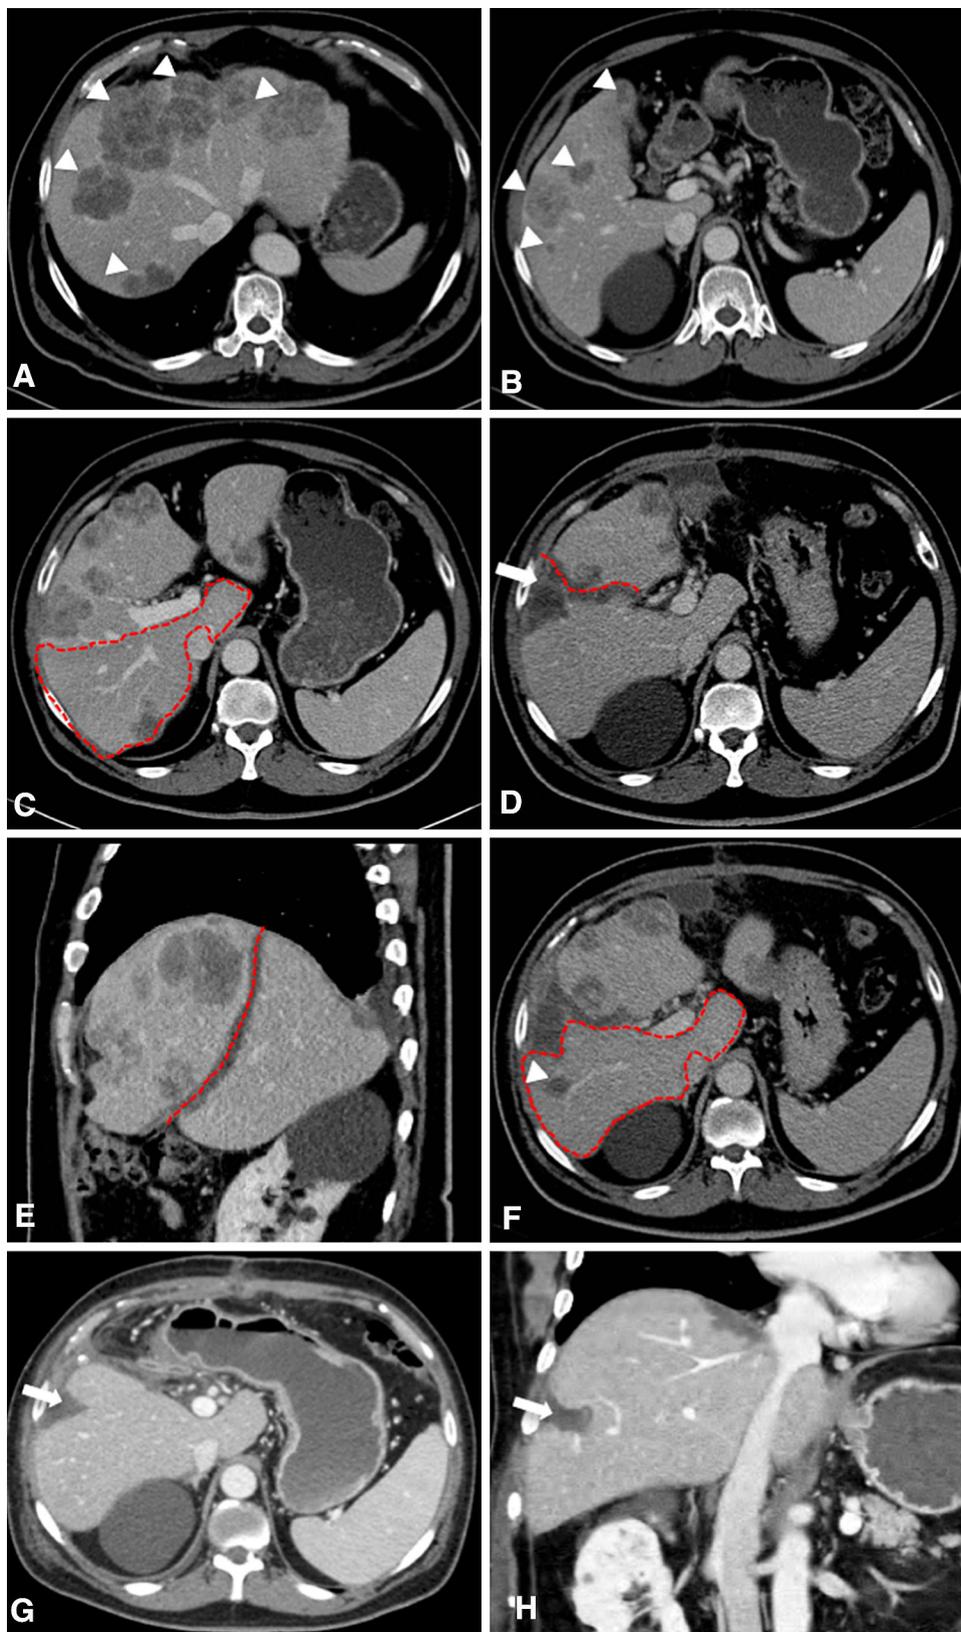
ALPPS variation: left ALPPS variation: A 58-year-old man with sigmoid colon cancer with multiple liver metastases. A In the preoperative images (IM1), there were 14 nodules, including B 4 nodules within segments VI, V, and IV (arrowheads). Prior to ALPPS (IM1) (C), the total liver volume was 2030 cm³, and segments I, VI, and VII were 540 cm³ in volume (25% of the total volume). Axial- (D) and sagittal (E)-enhanced CT images following ALPPS S1 indicate both the liver partition (red dotted line) separating segments I, VI, and VII from the remaining liver and a nodulectomy at segment VI (arrow). F Axial-enhanced CT images after the first surgery (IM2); the red dotted lines indicate segment I and the transition of segments VI and VII. Twelve days after the first surgery, the right lateral segments increased in volume from 540 to 625 cm³ (an increase of 15%, which represents 30% of the total liver volume). There was still a lesion adjacent to right hepatic vein (arrowhead). Axial (G) and coronal (H) follow-up-enhanced CT images 4 weeks after hepatectomy demonstrate the remnant liver (segments I, VI, and VII) and the nodulectomy areas (arrow).
